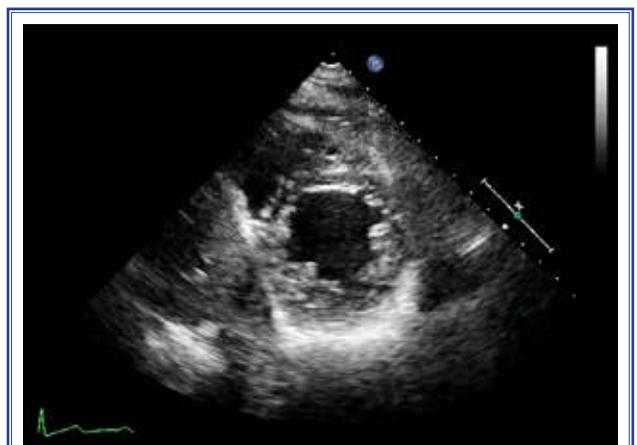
Parasternal short axis view of echocardiography showing LVNC.
